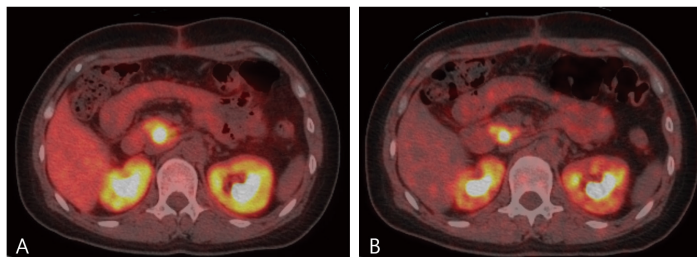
Axial 18F-FDOPA PET/CT fusion image showing on increased uptake in the head of pancreas on both 10min (A) and 1hr (B) images.
